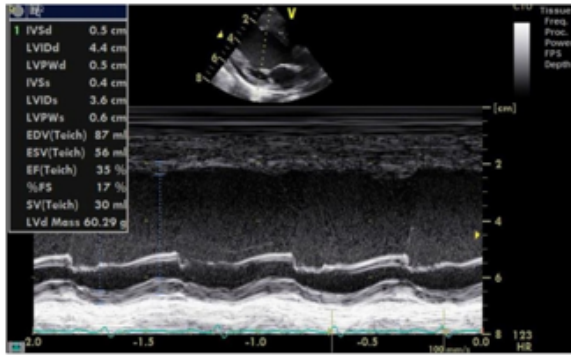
Parasternal Long axis view showing severe LV dysfunction (EF 35 %)+
